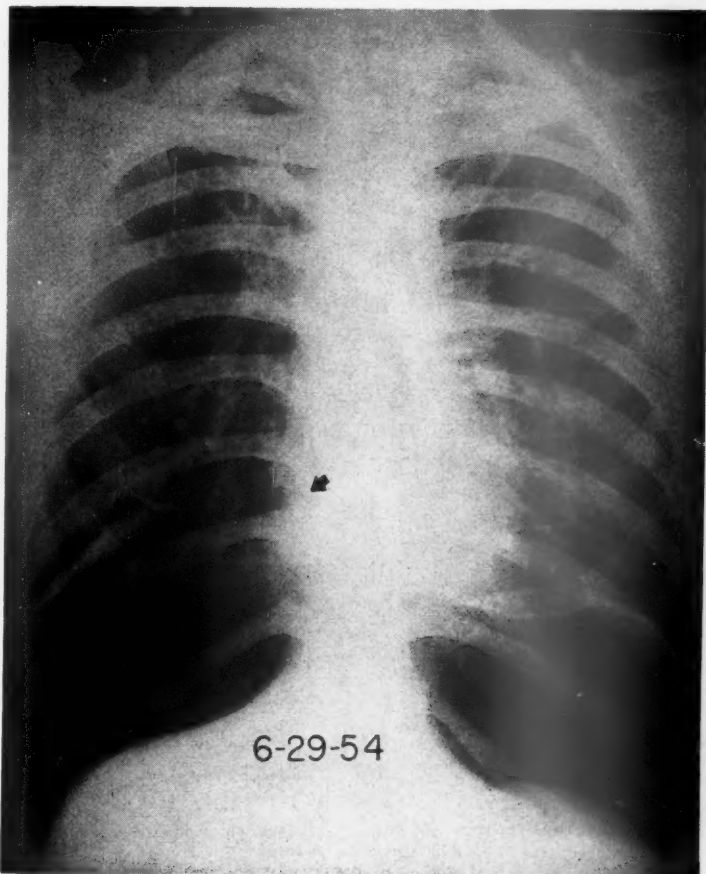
Chest roentgenogram three weeks prior to pneumothorax. Thinning of right dome of diaphragm still present.
